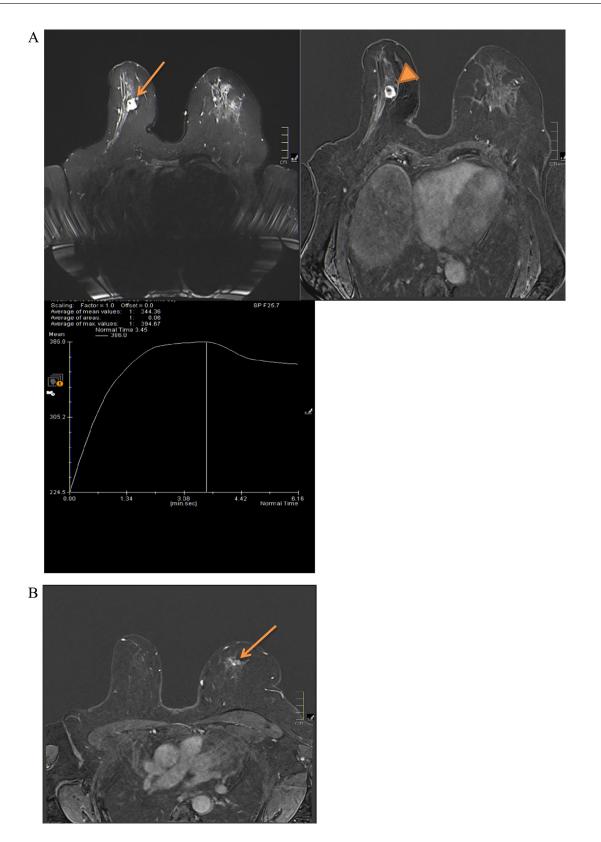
(A) Magnetic resonance imaging (MRI) of right breast: a well-defined round mass in the right breast at the 6 o'clock position. The lesion was highly intense on fat-saturated T2-weighted images (arrow), and showed benign-appearing kinetics with gradual and persistent enhancement (arrowhead) (typical MRI features of mucinous carcinoma). (B) MRI left breast: a small speculated hypervascular lesion seen in the left breast at the 11 o'clock position. The lesion was isointense on T1- and T2-weighted images.
